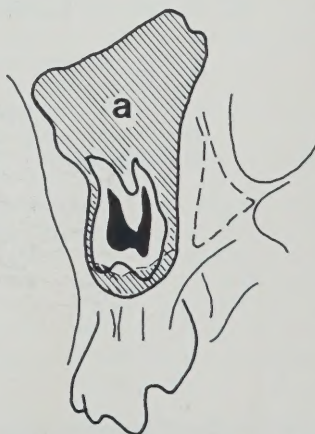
Sketch from P.A. skull radiograph. (a) Maxillary sinus.
